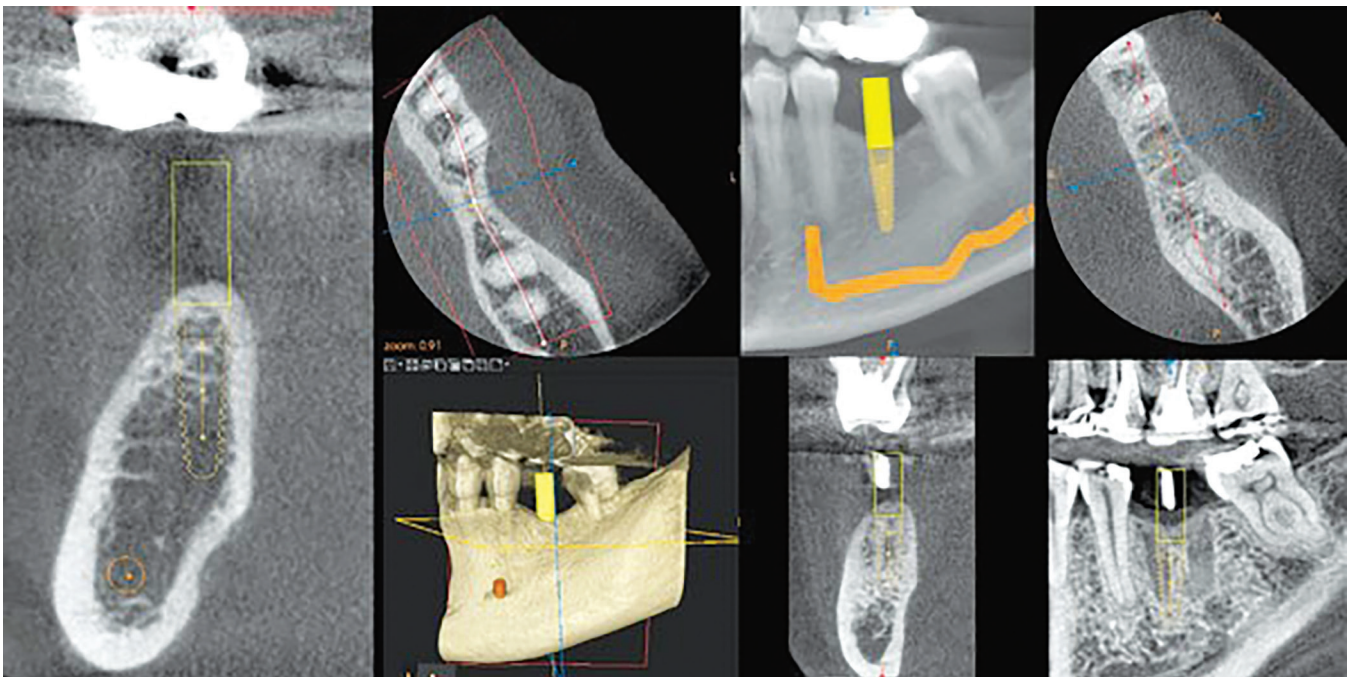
The CBCT-guided implant
